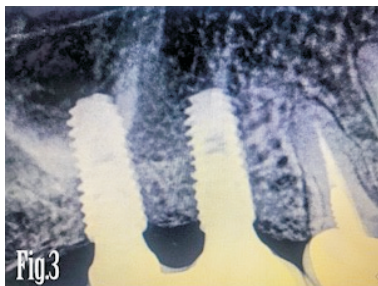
Radiograph showing optimum bone formation and bone height gain of 5-6mm, 6 months after augmentation.
